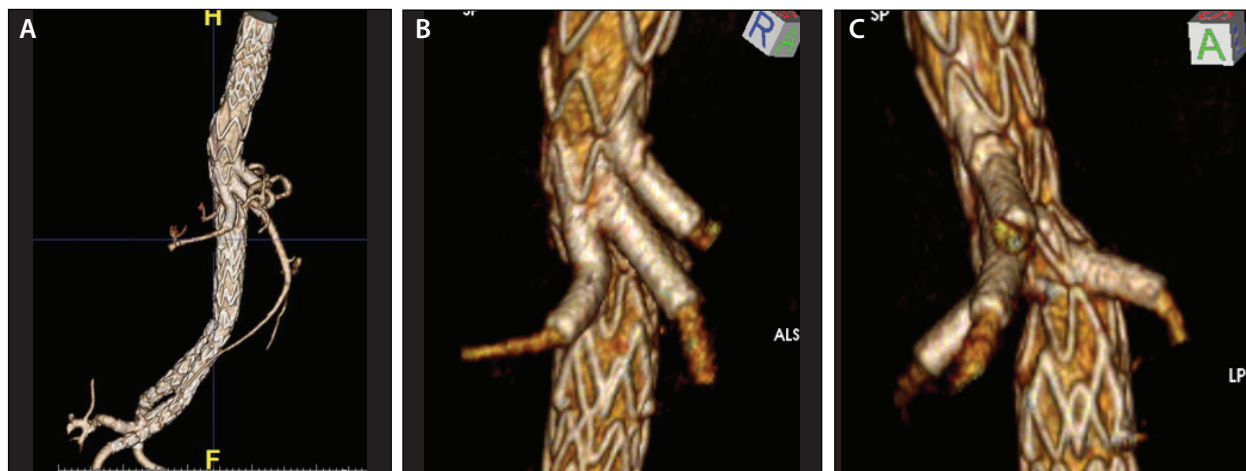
Four-week follow-up CT scan showing good proximal seal, plus seal and patency in all four branch vessels.
